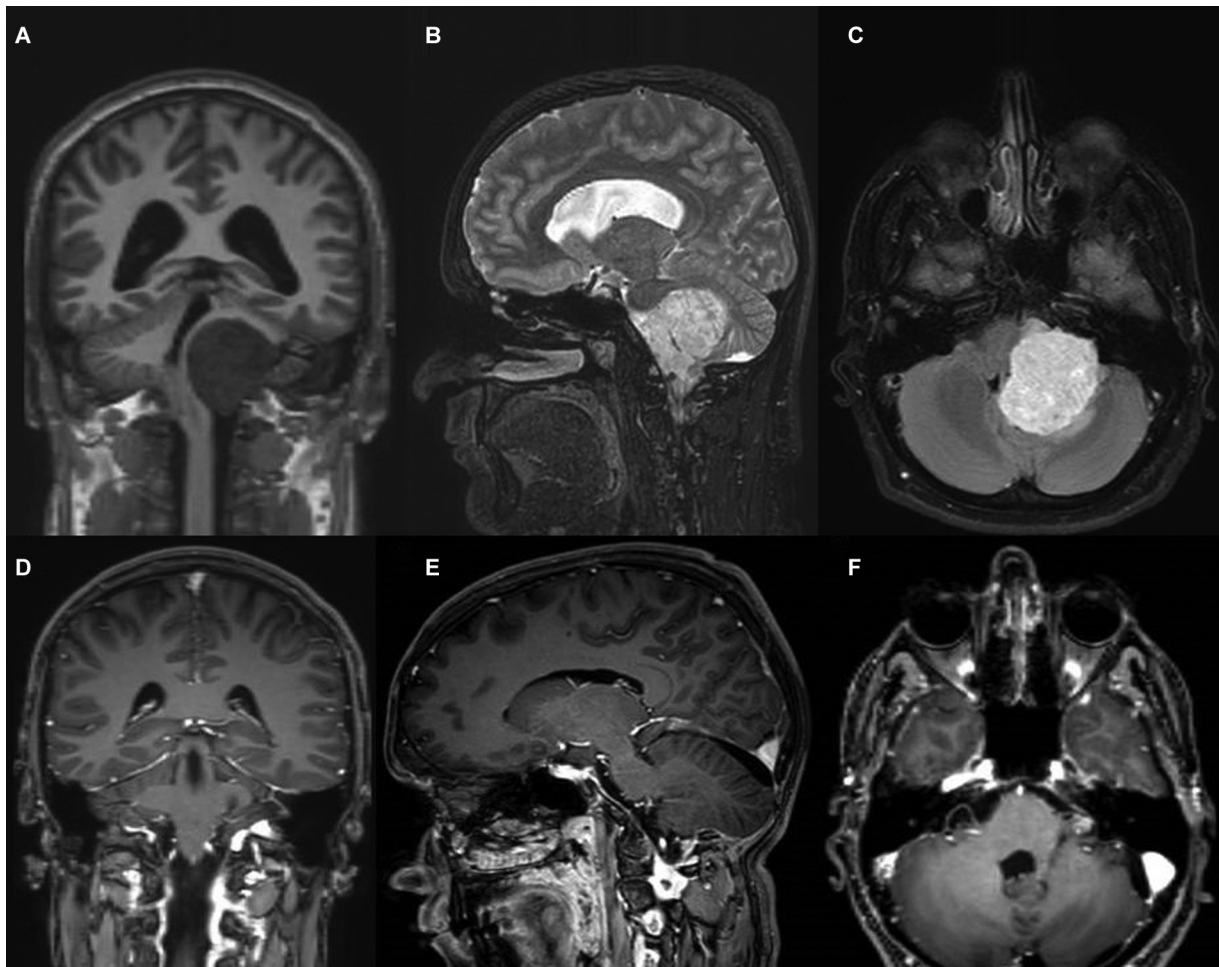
(A) T1-weighted coronal magnetic resonance imaging (MRI) scan showing the tumor invading down the foramen magnum. (B) T1-weighted contrast-enhanced sagittal image showing a giant tumor seated on a large dural base. (C) Fluid-attenuated inversion recovery-weighted contrast-enhanced axial section image showing fourth ventricular compression. (D–F) Control-enhanced MRI scan performed 6 months postoperatively, surgical trace from which the tumor was removed in the coronal section, no residual tumor or recurrence is observed.
